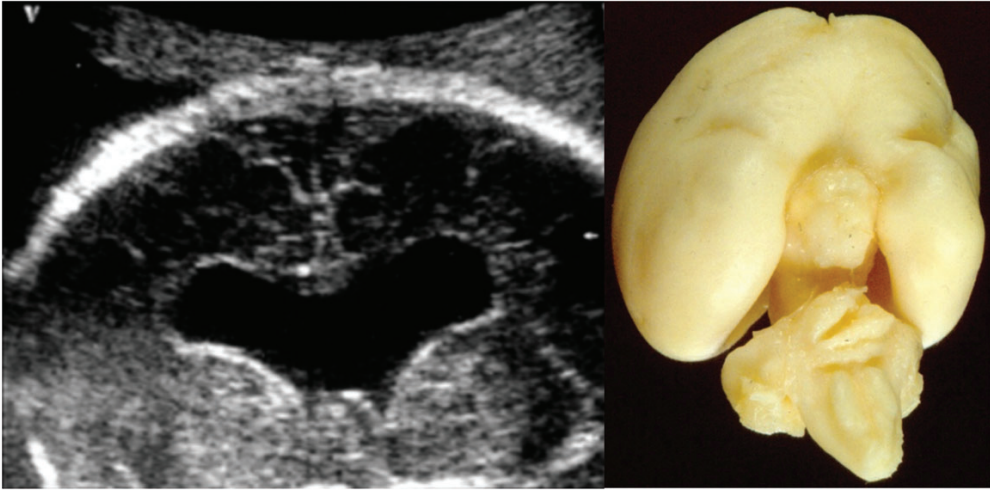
Ultrasound image and postmortem photography of an 18-week fetus with lobar holoprosencephaly, 1993. The ultrasound image is a coronal section through the brain with open connection between the lateral ventricles. There is no corpus callosum and no septa pellucida. Associated anomalies: premaxillary agenesis, polycystic kidneys, and cloacal agenesis.
